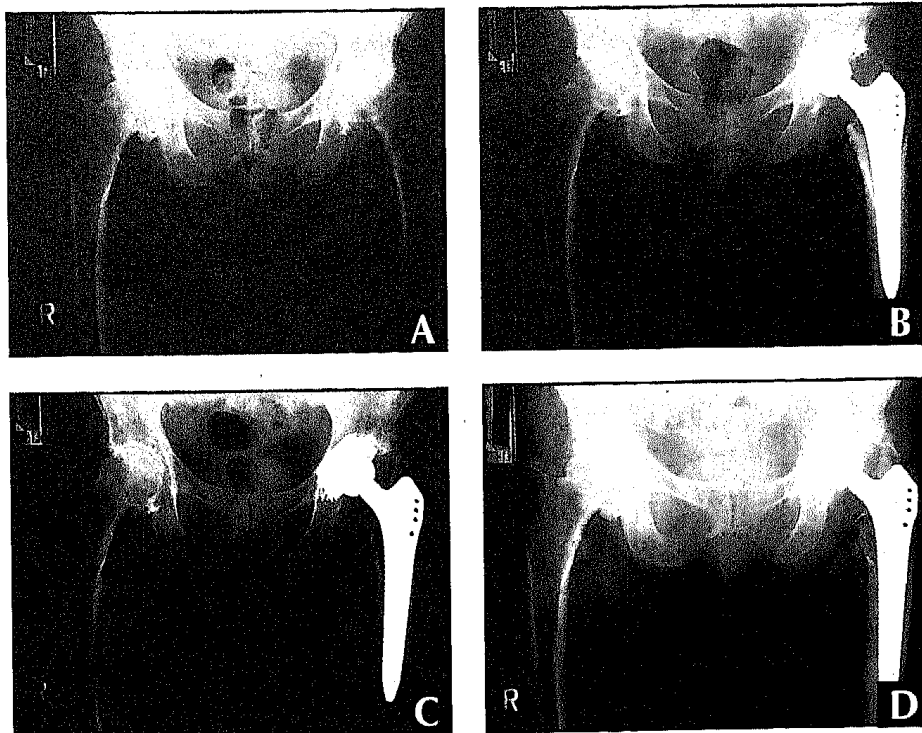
Preoperative radiograph (A) of a 68-year-old woman with hypertrophic osteoarthritis at low risk for heterotopic ossification. Radiograph taken 1 week postoperatively (B) demonstrates an avulsion of the greater trochanter tip. Radiograph taken 3 months postoperatively (C) shows apparent grade II heterotopic ossification while the radiograph taken 12 months postoperatively (D) shows apparent grade III heterotopic ossification with no functional impairment.
